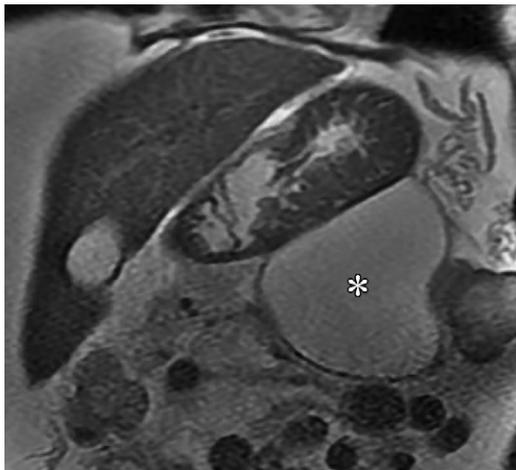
Pseudocyst in a 48-year-old woman. Coronal T2-weighted MR image obtained 8 weeks after onset of pancreatitis shows a large homogeneous collection in the lesser sac (*) with uniformly hyperintense fluid signal and no necrotic components, findings that are consistent with pseudocyst.
